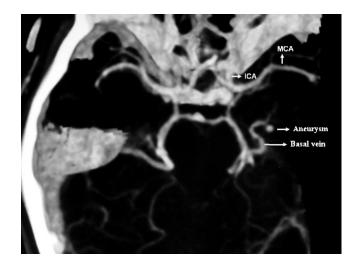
Patient 1: Computed tomographic angiography demonstrates distal AChoA aneurysm. This is the first demonstration in the literature. In this study, AChoA itself could not be visualized because of the small size.
